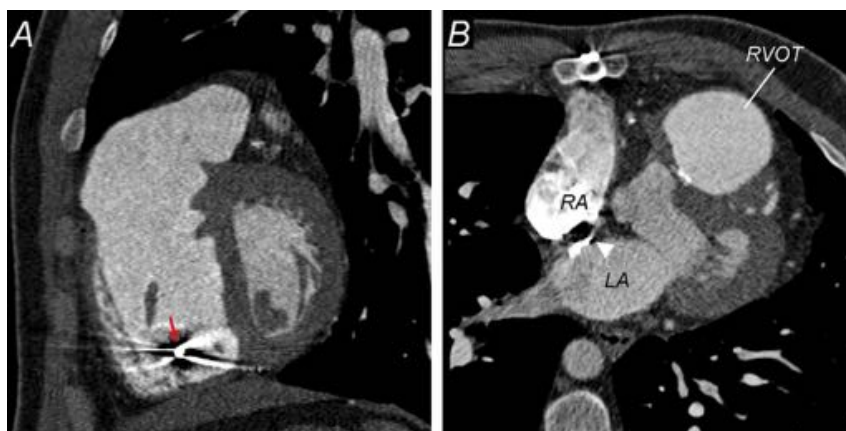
CT in a patient with repaired TOF and severe PR who is a candidate for PV replacement. (A) Note pacemaker lead in the right ventricle (arrow) and proximity of the RVOT to the sternum. (B) Note patent foramen ovale (arrowhead). LA, Left atrium; RA, right atrium.
